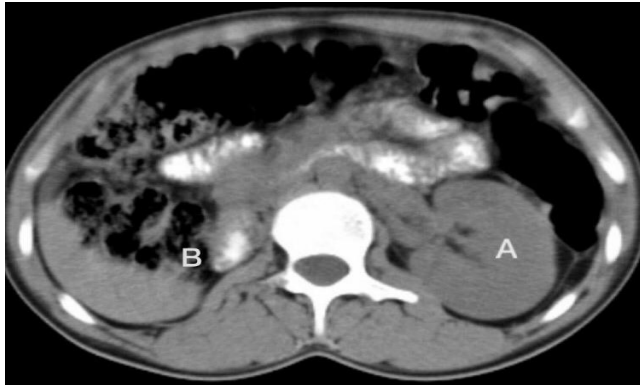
Axial CT image abdomen. Right sided renal agenesis. A. Left kidney with compensatory enlargement. B. Right renal agenesis.
